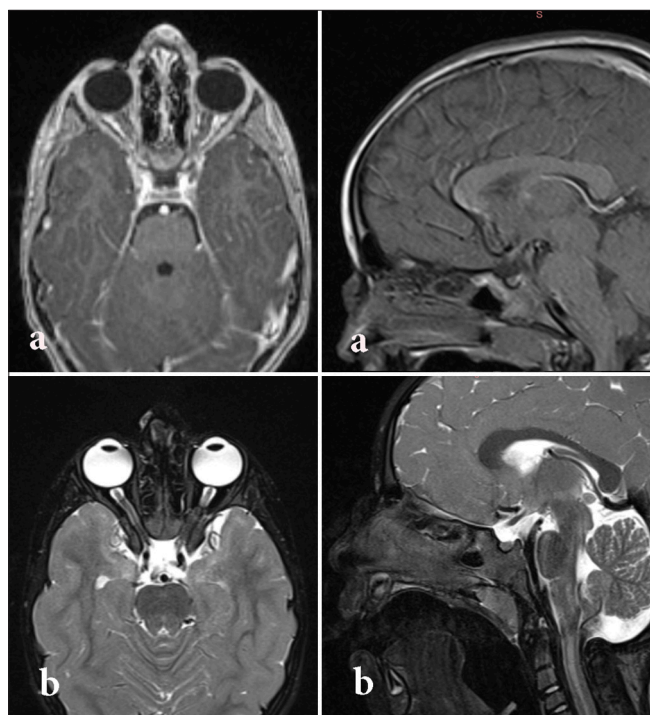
Postoperative magnetic resonance imaging showing no evidence of recurrence at 3 years of age with mildly hypertrophic scar. (a) T1 axial and sagittal images. (b) T2 axial and sagittal images.
